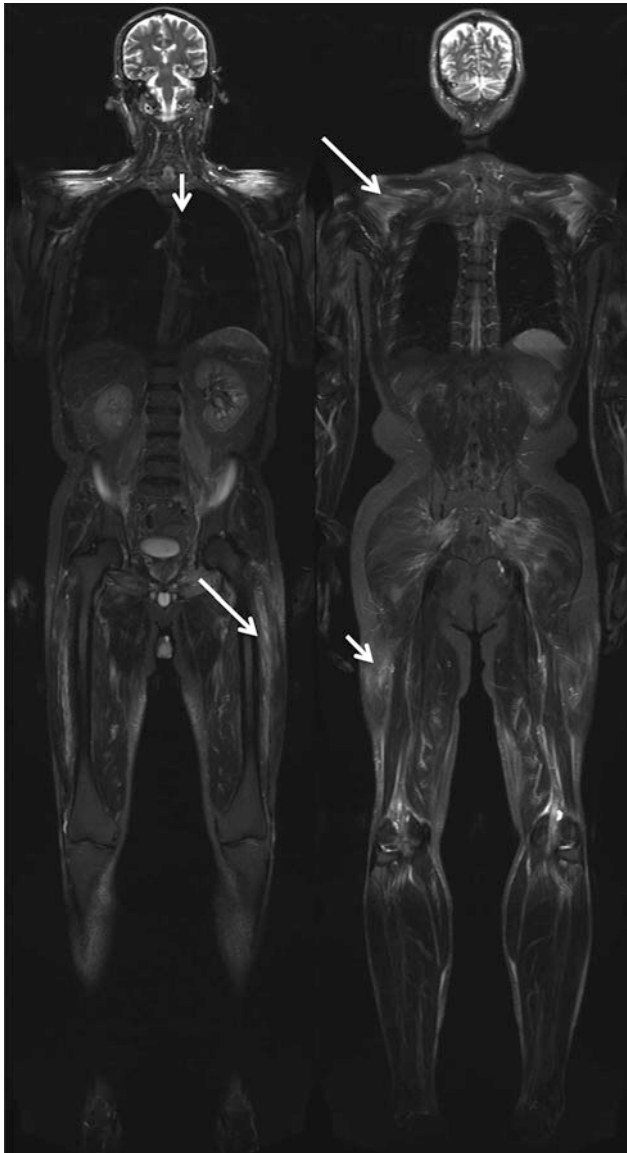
Whole-body STIR MRI showing diffuse subcutaneous (*short arrows*) and muscle edema (*long arrows*) characteristic of dermatomyositis. Muscle edema is accentuated in the shoulder girdle, pelvic girdle, and the thighs (image courtesy of Prof. Dr. M.-A. Weber, Heidelberg)
